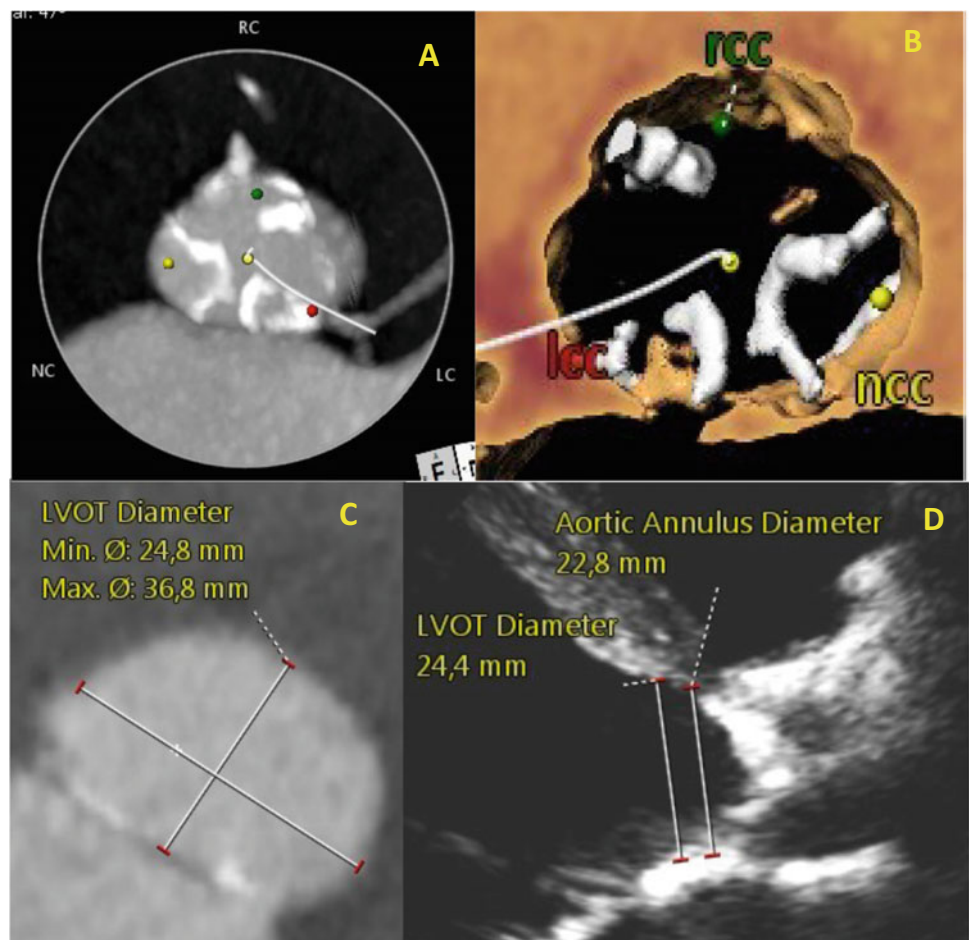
CT scan in 2016 before TAVR. a and b CT images showing the tricuspid aortic valve with the marginal and basal calcification of the leaflets typical for radiation-induced valve disease. c Measurement of LVOT diameter by CT. CT planimetry is usually more accurate than the measurement based on echocardiography which can be hampered by calcification and by the shape of LVOT. The cross section of the LVOT is elliptical and even the minimal diameter is bigger than that measured by echo (d). That results in a larger estimated LVOT area and VTI. d Measurement of LVOT diameter with the use of echocardiography. CT—computed tomography. LVOT—left ventricular outflow tract. TAVR—transcatheter aortic valve replacement. VTI—Velocity time integral
